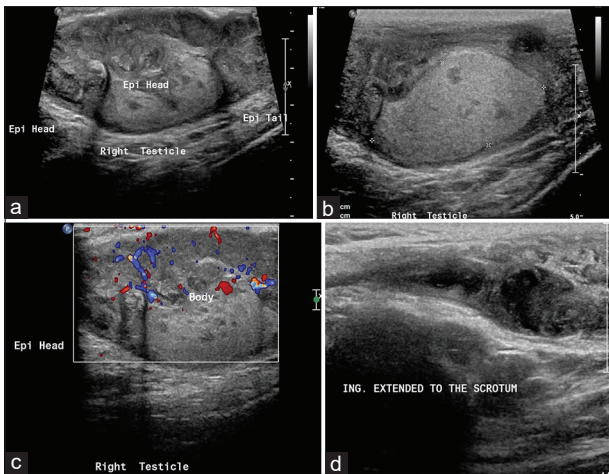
(a-d) The ultrasonography images of a 32-years male with the right testicular showing swelling and deformed shape with 4.34 cm × 2.28 cm (b). Image shoes heterogeneous echogenicity with multiple patches of hypoechoic spots distributed throughout the testicle (a). The right testicle shows hypervascularity with multiple, hypoechoic, solid nodules in the most substantial measures 4.2 mm × 5.8 mm throughout the testicular (a). The Right epididymal head and body are enlarged, heterogeneous in echogenicity with massive vascularity, and are hypervascular (c). There is a heterogeneous fluid collection noted that the most inferior aspect of the inguinal canal. The extra testicular abuses extended to the scrotum (d)
